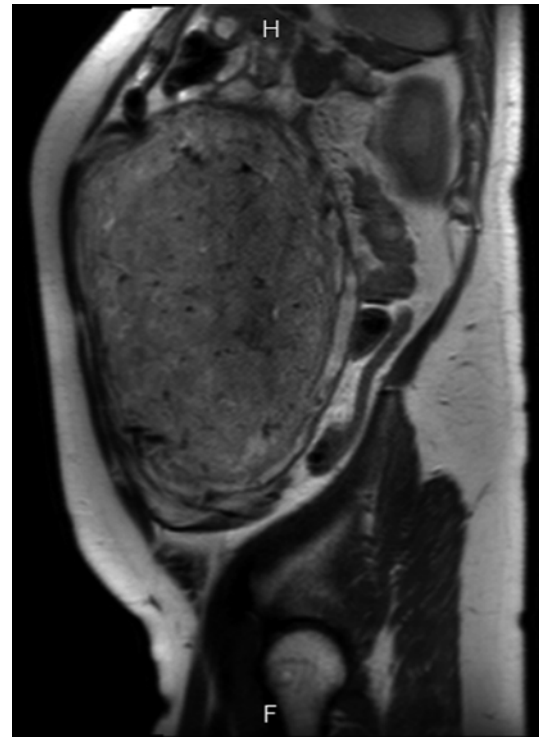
A sagittal scan by MRI of a large pedunculated fibroid in an early pregnant women, with initial fibroid torsion on its axis (Courtesy of Prof. Dr. Josè Palacios de Jaraquemada)
